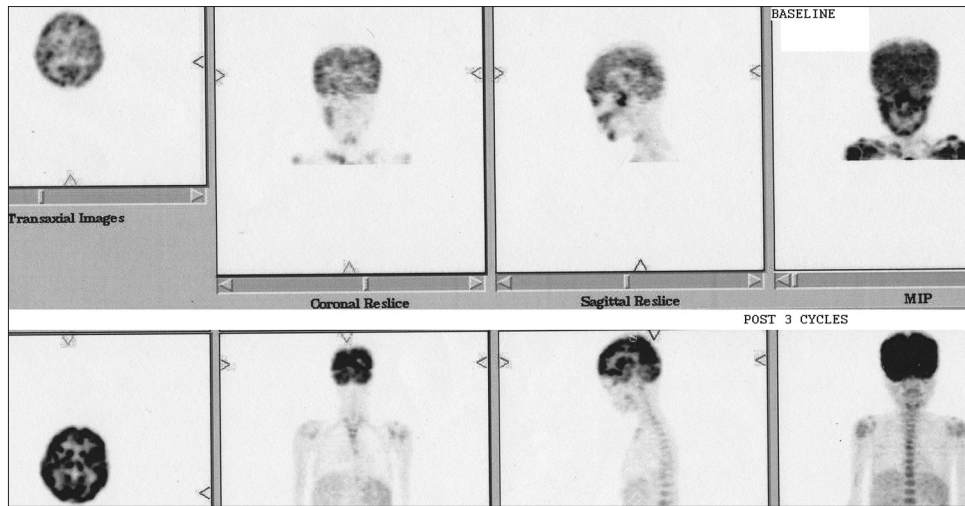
The images show marked treatment response with disappearance of “super scan”-like pattern, reduction in number, size, and metabolic activity of the lesions that were shown in the earlier scan. SUV_{max} of the occipital region of the brain increased from the previous value of 3.3 to 9.9. For rest of the brain, the SUV_{max} increased from 2.9 to 8.6
